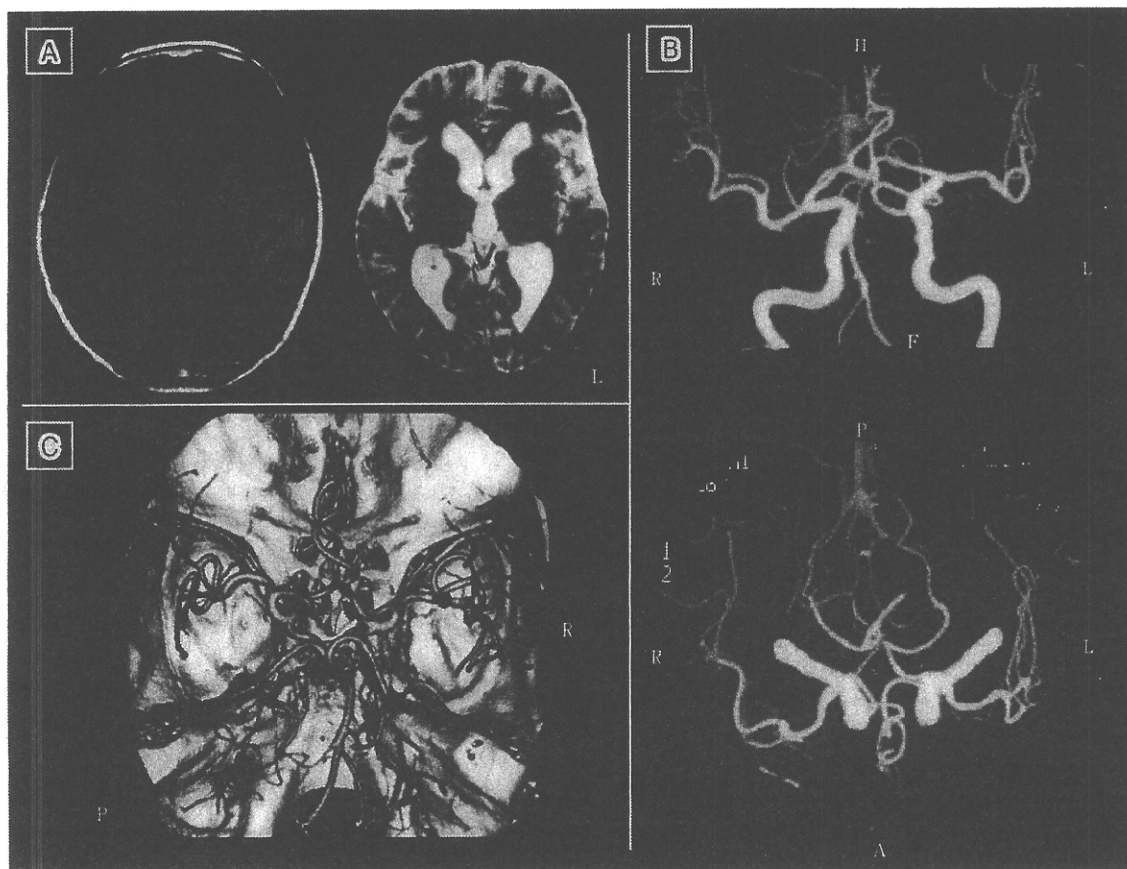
Magnetic resonance imaging (MRI) and computed tomography (CT) angiography.
